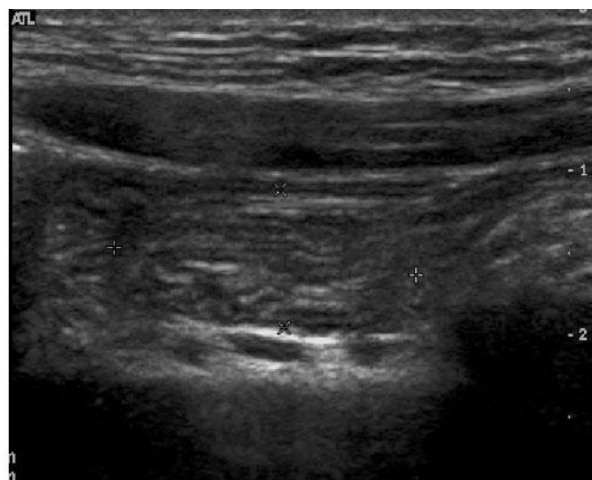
Ultrasonographic longitudinal plane images of a 7-year-old boy with abdominal pain and typical transient small bowel intussusception shows the sandwich sign (cursors).
